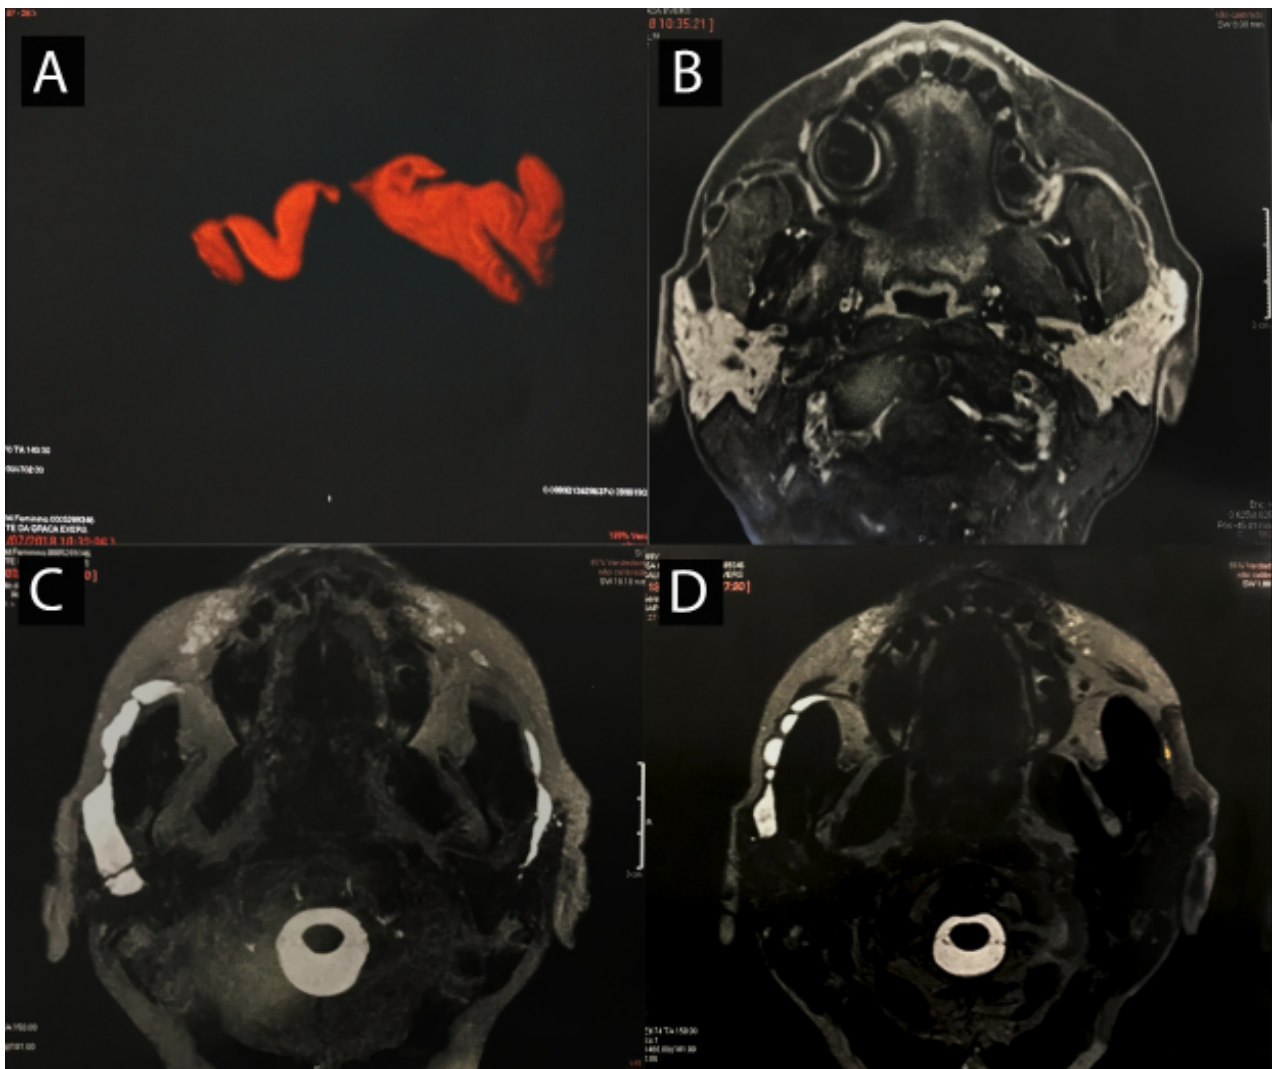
MR sialography shows in (A) (T2-weighted image) stricture of the right main duct followed by stenosis. (B) Axial section (T1-weighted image) of the right and left parotid glands and its main ducts. (C) Axial section (T2-weighted image) ductal stricture, ectasia, and sialoceles in the right parotid gland, and stenosis in the left parotid gland. (D) Axial section (T2-weighted image) shows stenosis of the right parotid gland.
